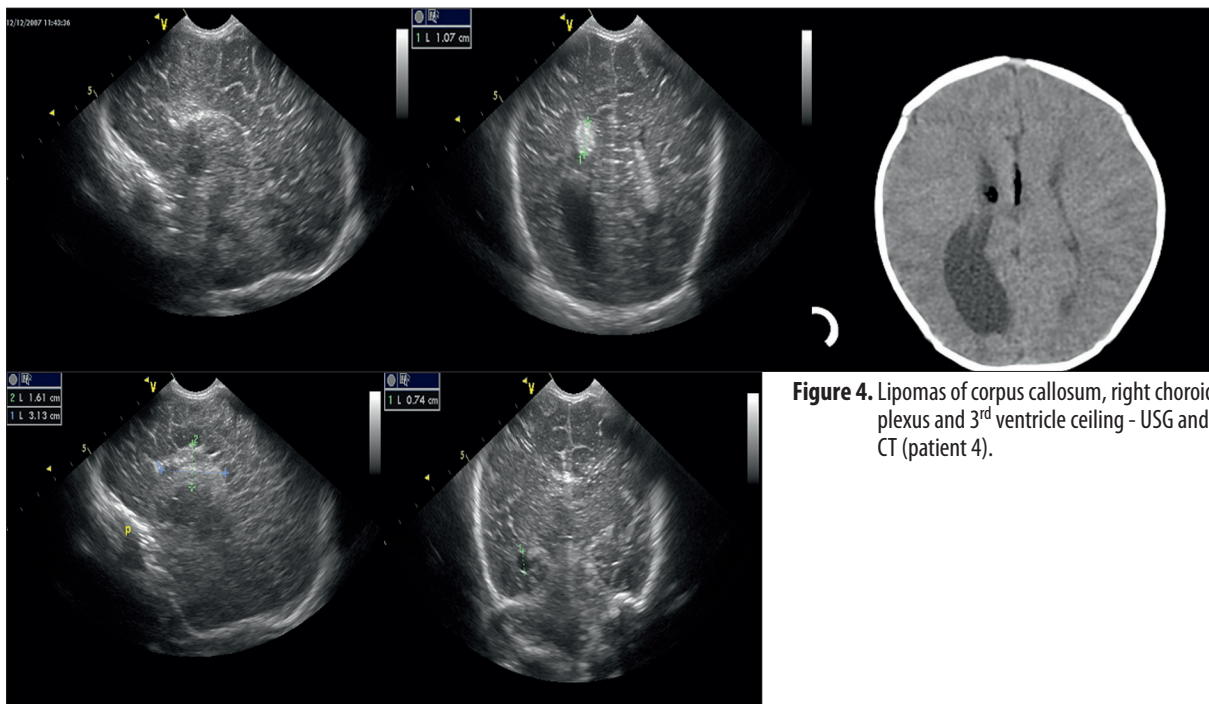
Lipomas of corpus callosum, right choroid plexus and 3rd ventricle ceiling - USG and CT (patient 4).
